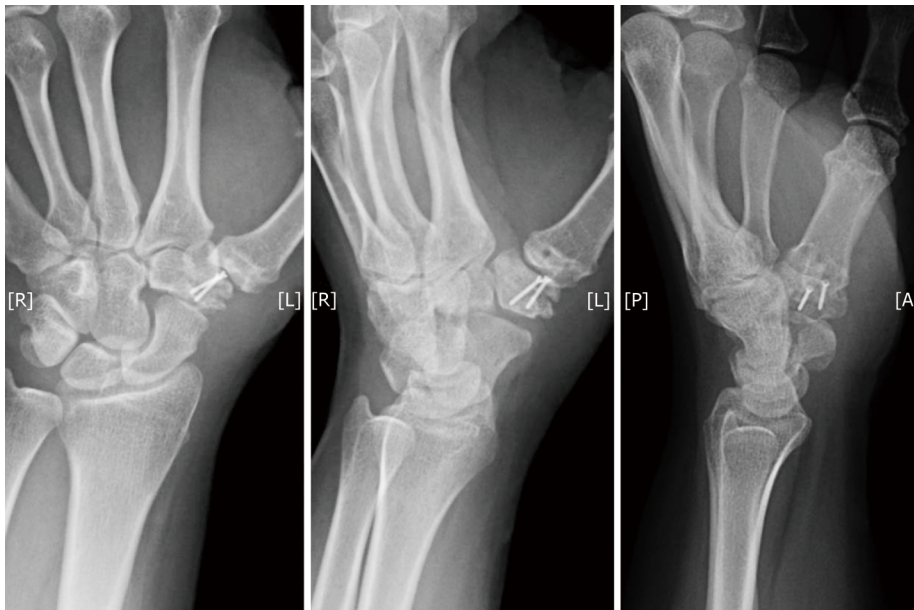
Postoperative x-rays after subtraction hemi-arthroplasty.
